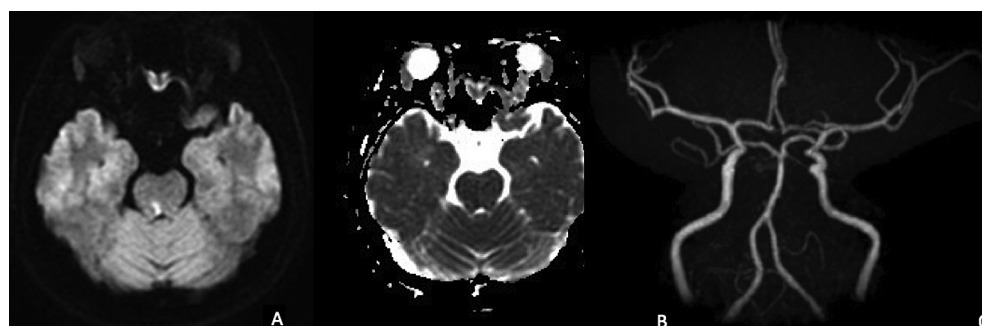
Magnetic resonance imaging and angiography performed 24 hours after symptoms onset. (A) Diffusion-weighted imaging shows a high signal intensity in the right upper paramedian pontine tegmentum adjacent to the fourth ventricle and (B) apparent diffusion coefficient shows low signal intensity in the same location, compatible with acute infarction. (C) Magnetic resonance angiography shows no obvious luminal narrowing or focal stenosis in intracranial arteries.
